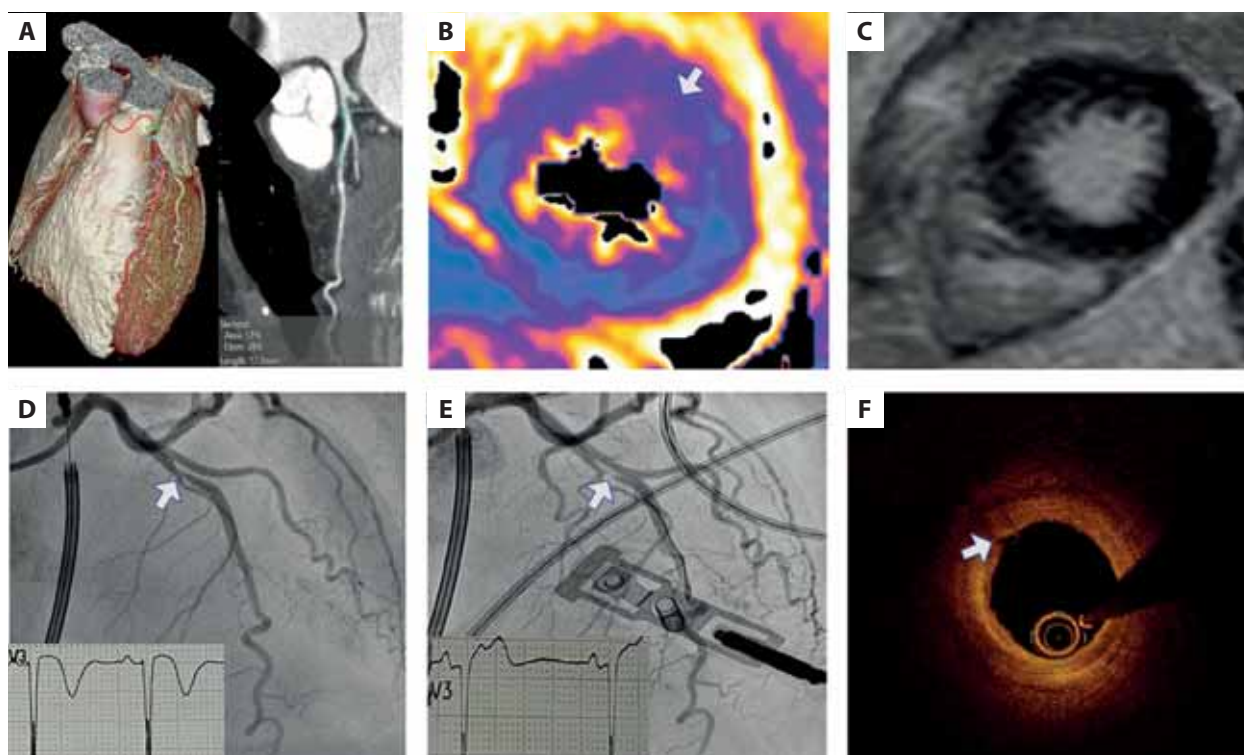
A. Computed tomography angiography; noncalcified plaque with 40% stenosis in the left anterior descending coronary artery. B, C. Cardiac magnetic resonance; anterior myocardial edema on T2 mapping (B) without late gadolinium enhancement (C). D, E. Severe spasm in the mid-anterior descending coronary artery. F. Optical coherence tomography, small erosion in the mid segment
